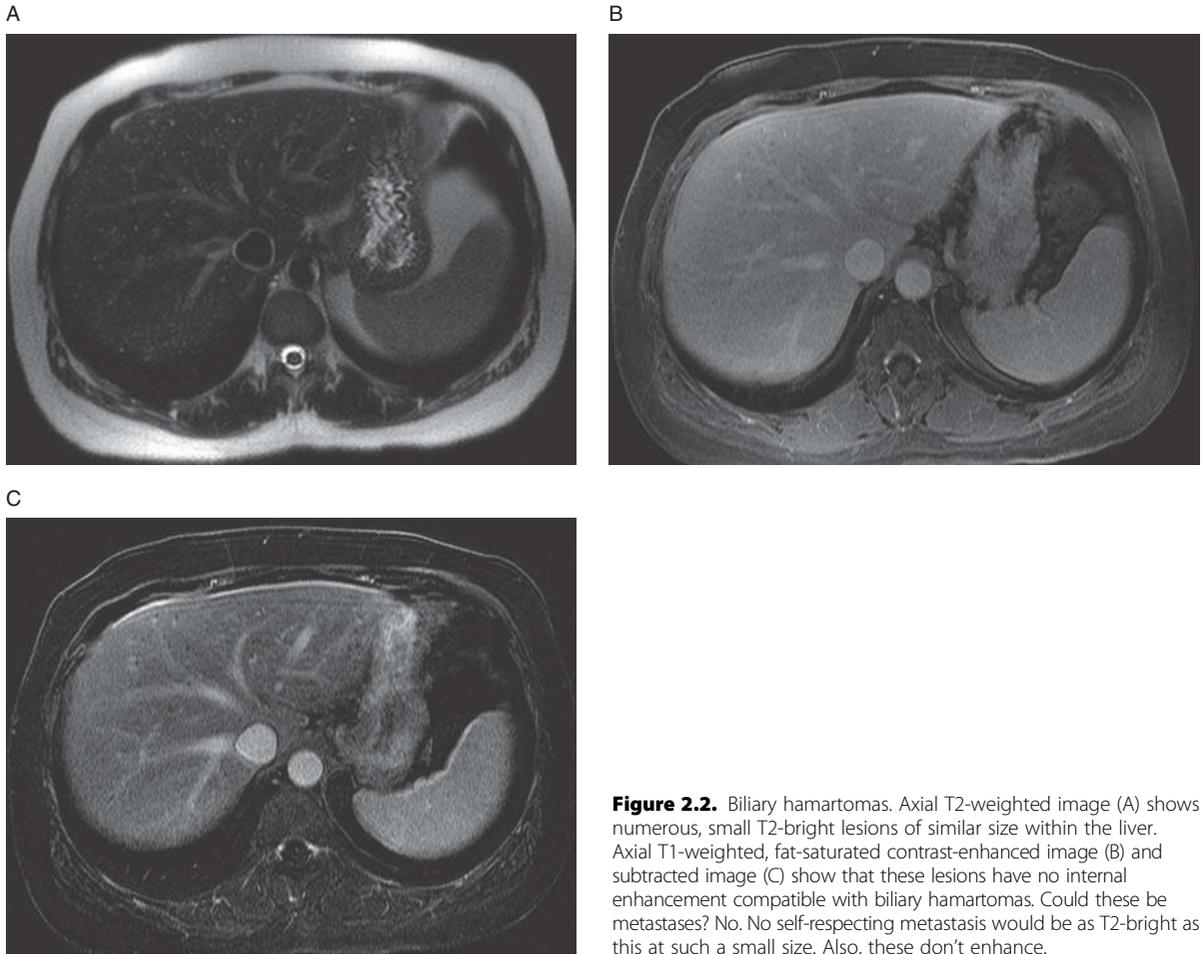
Biliary hamartomas. Axial T2-weighted image (A) shows numerous, small T2-bright lesions of similar size within the liver. Axial T1-weighted, fat-saturated contrast-enhanced image (B) and subtracted image (C) show that these lesions have no internal enhancement compatible with biliary hamartomas. Could these be metastases? No. No self-respecting metastasis would be as T2-bright as this at such a small size. Also, these don't enhance.
